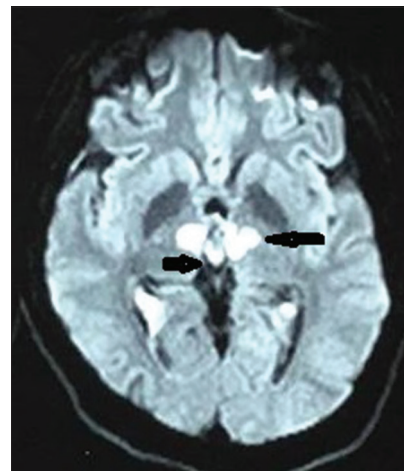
Magnetic resonance imaging diffusion-weighted imaging showing bilateral infarct postoperatively (arrows)
